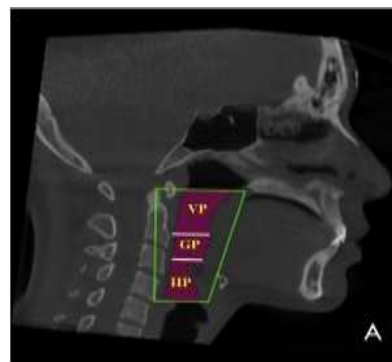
VP: velopharyngeal airway volume; GP: glossopharyngeal airway volume; HP: hypopharyngeal airway volume (Tseng YC, Tsai FC, Chou ST, Hsu CY, Cheng JH, Chen CM. Evaluation of pharyngeal airway volume for different dentofacial skeletal patterns using cone-beam computed tomography. Journal of Dental Sciences. 2021 Jan 1;16(1):51-7.)⁽⁷⁾
